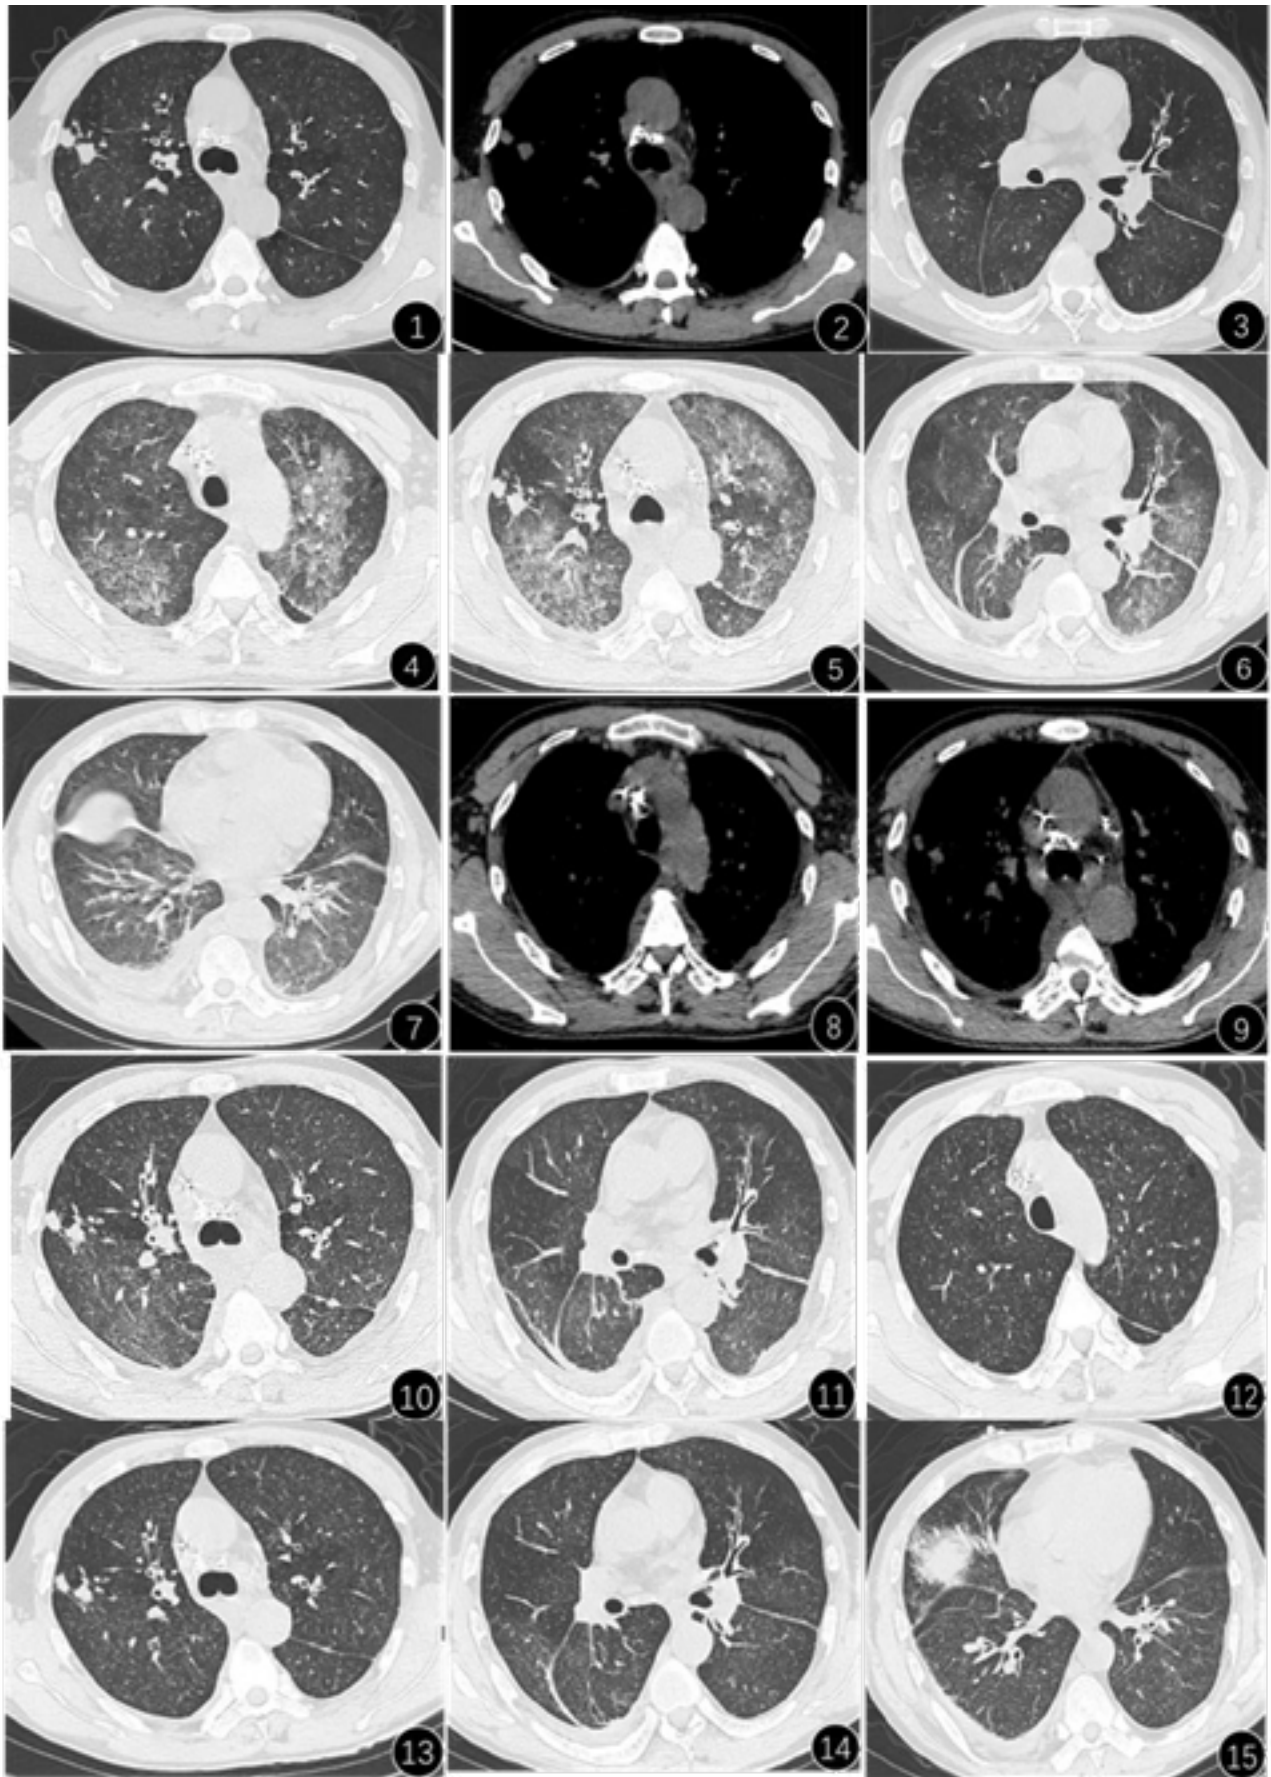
Chest CT scans of the patient at different 121 stages of disease.
